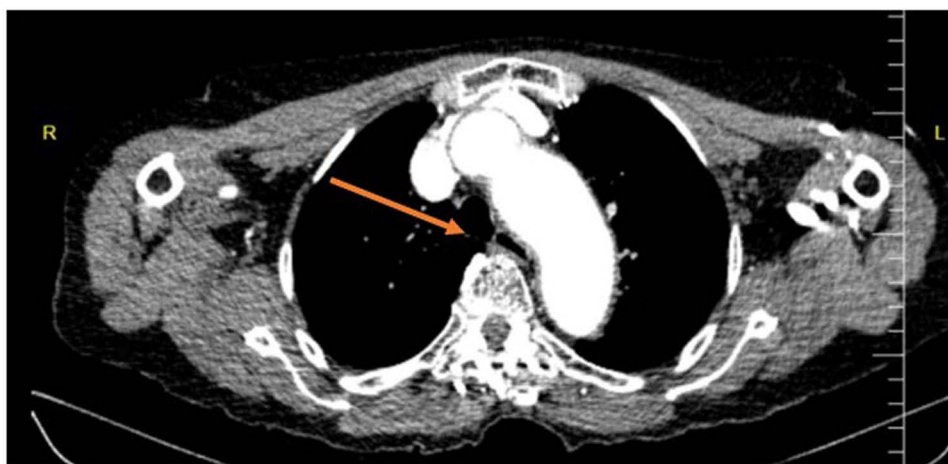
A CT image at the upper thoracic level showing the enlarged arch of the aorta compressing the esophagus. The Orange arrow indicates the compressed esophagus.
